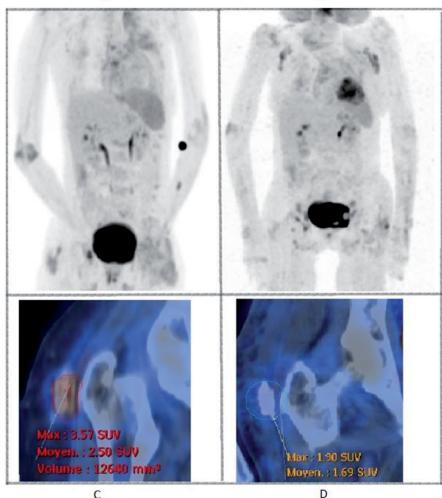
Positron emission tomography with [¹⁸F]-fluorodeoxyglucose (FDG) integrated with computed tomography before (A, C) and 4 months after (B, D) starting anakinra in maximum-intensity-projection (A, B) and coronal fused (focused on the gluteus maximus muscle) (C, D) images showing in the latter a 46% standardised uptake value reduction (delta SUV max). *Acquisition from the base-skull to the base-thigh one hour after injection of 2.5 MBq/kg of FDG.*
